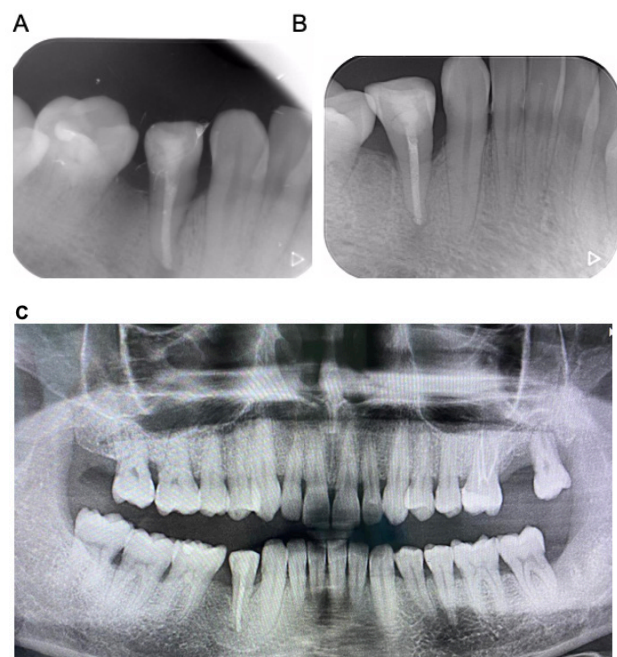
(A) periapical radiograph taken from the patient 3-month follow-up, (B) 6-month follow-up, (C) panoramic radiograph taken from the patient 5-year follow-up.
